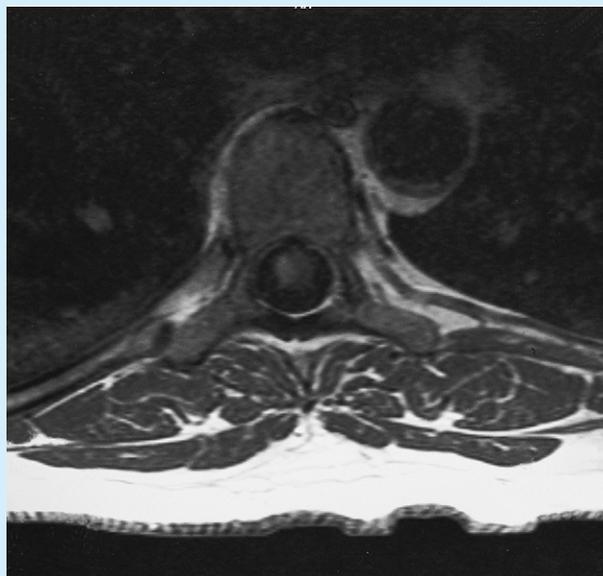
Magnetic resonance image Showing demyelinating lesion in the right side of the spinal cord.
